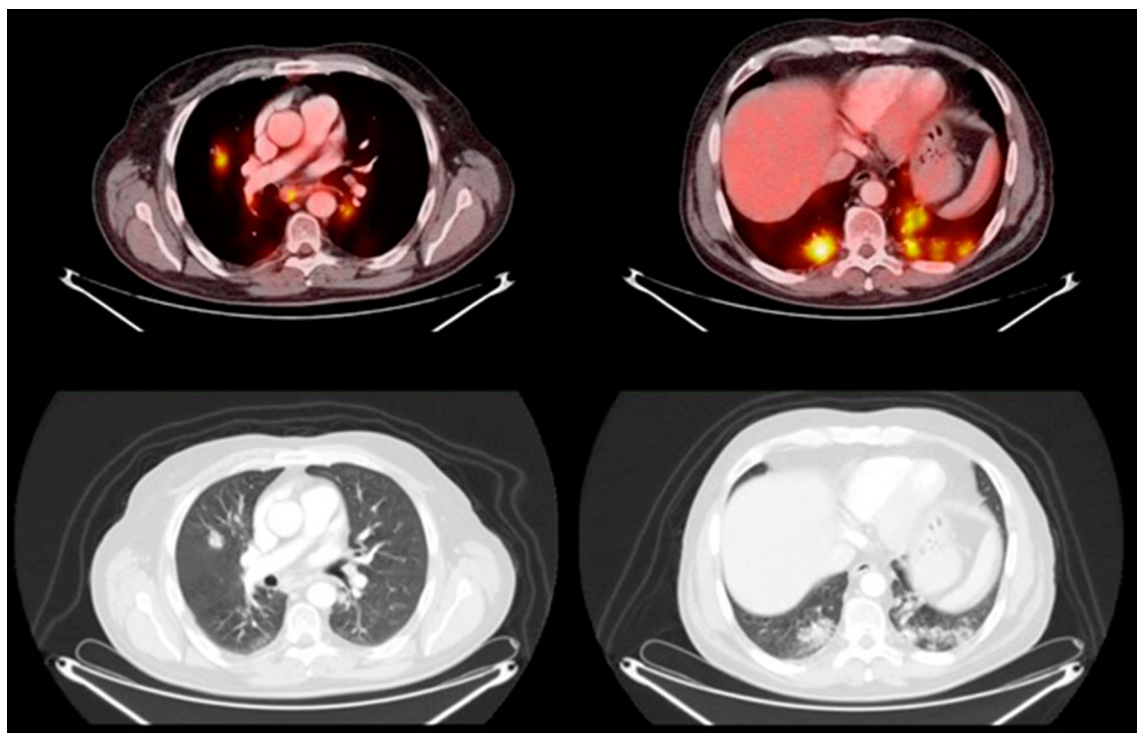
Lung metastasis at a nasopharyngeal squamous cell carcinoma FDG avid on PET/CT
